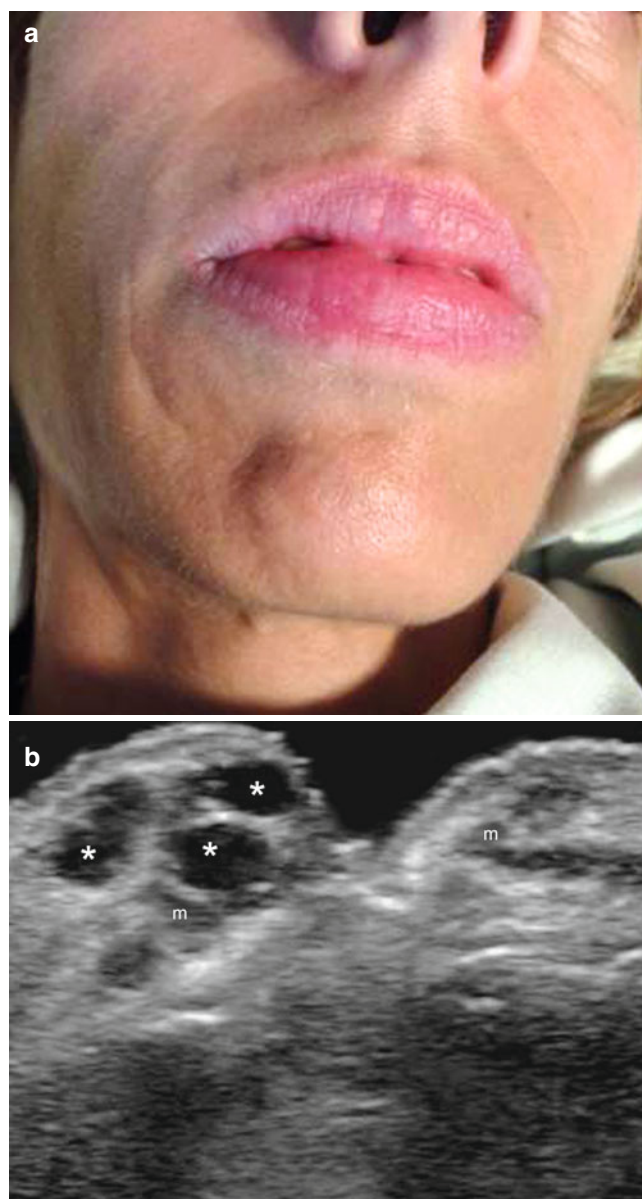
(a, b) Polyacrylamide (PAAG). (a) Clinical image of a patient who was injected with PAAG in the lips and mandible region. (b) Grey scale ultrasound image (longitudinal view) shows round and oval-shaped anechoic deposits (*) in the dermis and muscularis oris muscle (m) of the upper lip. The lower lip is unremarkable. *Abbreviation: m* muscularis oris muscle of the lip
